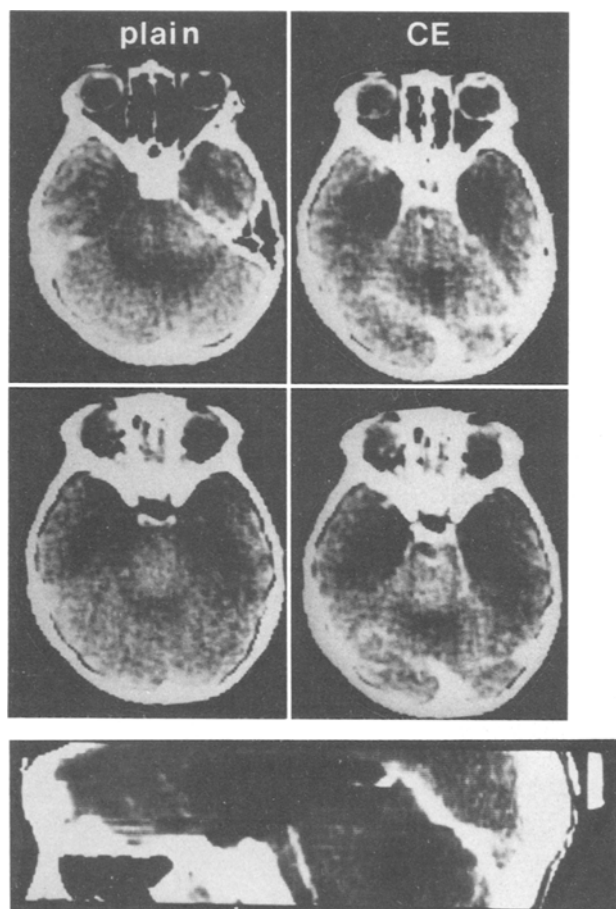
Computed tomography of patient showing acute deterioration. Slightly high density in the plain CT and no enhancement after contrast study
